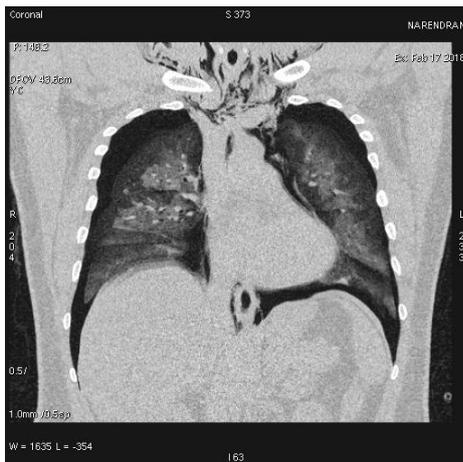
HRCT chest showing pneumomediastinum and pneumothorax.
